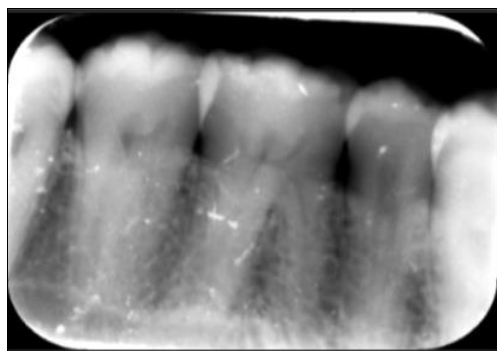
Preoperative radiographic image
